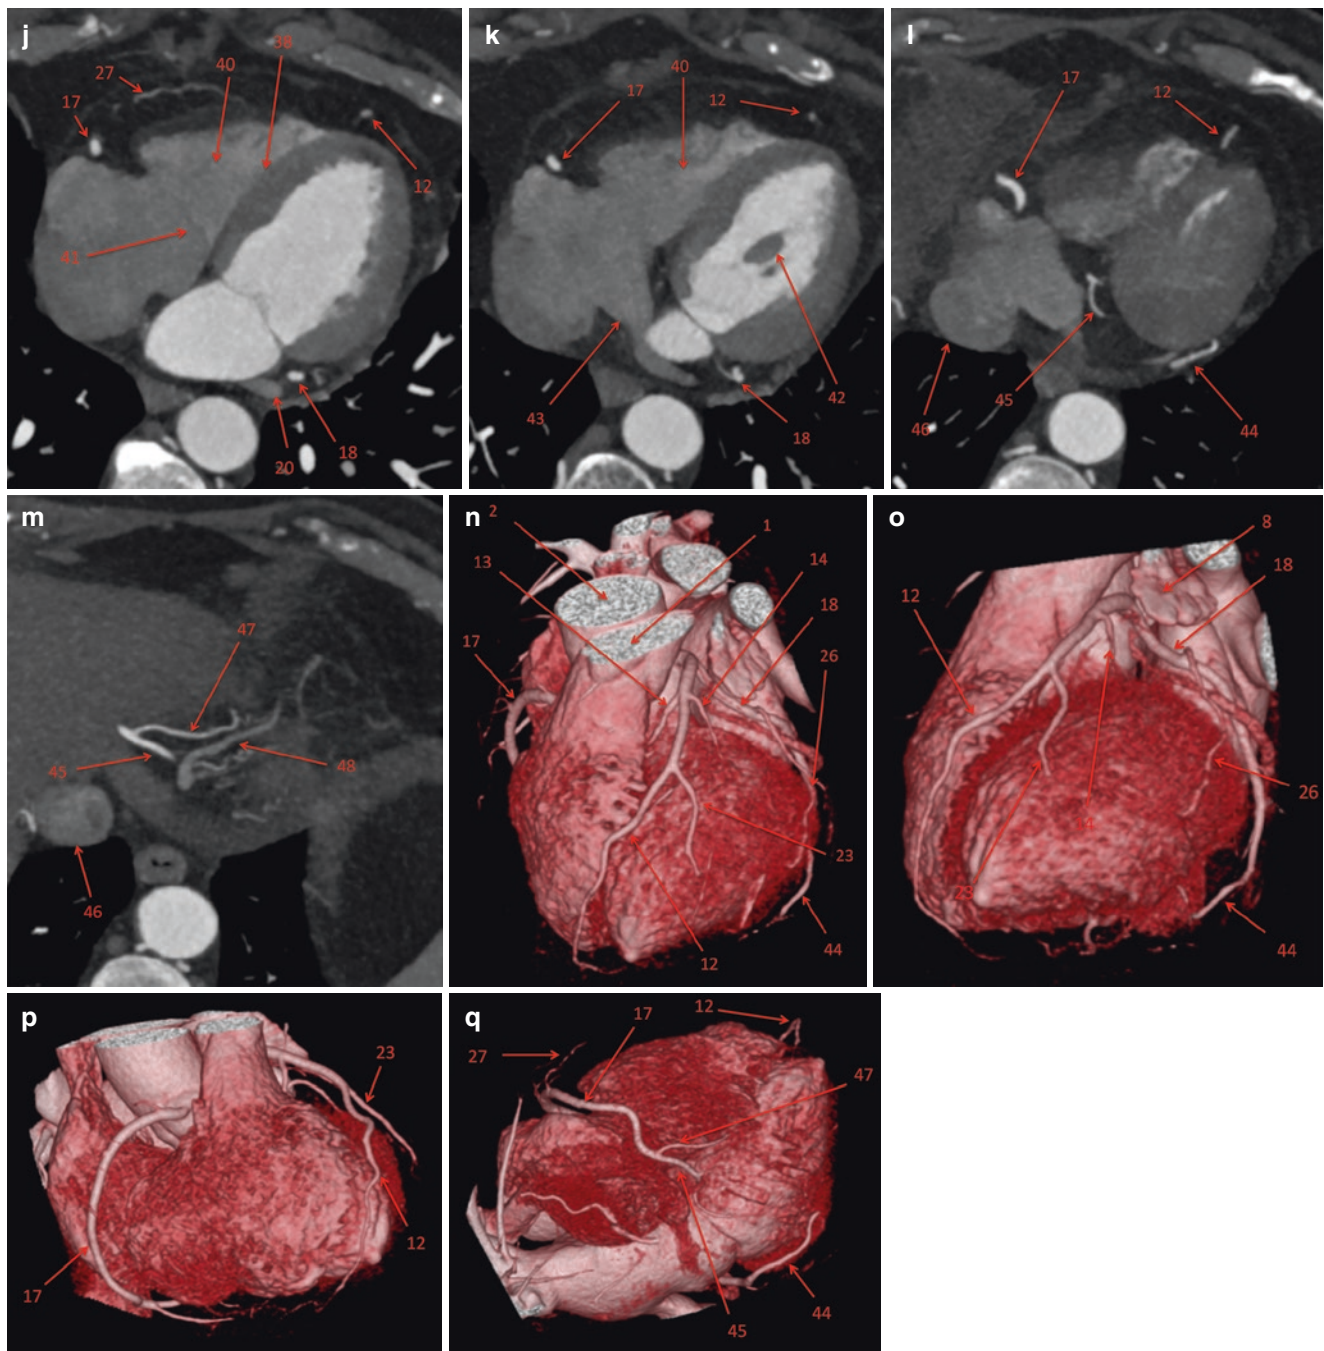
(a–q) Axial CT cardiac anatomy. 1. Main pulmonary artery. 2. Ascending thoracic aorta. 3. Descending thoracic aorta. 4. Right pulmonary artery. 5. Superior vena cava. 6. Left superior pulmonary vein. 7. Left main coronary artery. 8. Left atrial appendage. 9. Right atrial appendage. 10. Right superior pulmonary vein. 11. Left atrium. 12. Left anterior descending coronary artery. 13. First septal perforator. 14. First diagonal branch. 15. Left inferior pulmonary vein. 16. Conus artery. 17. Right coronary artery. 18. Left circumflex coronary artery. 19. Conus. 20. Great cardiac vein. 21. Coumadin ridge. 22. Right middle pulmonary vein. 23. Second diagonal branch. 24. Sinoatrial nodal artery. 25.
